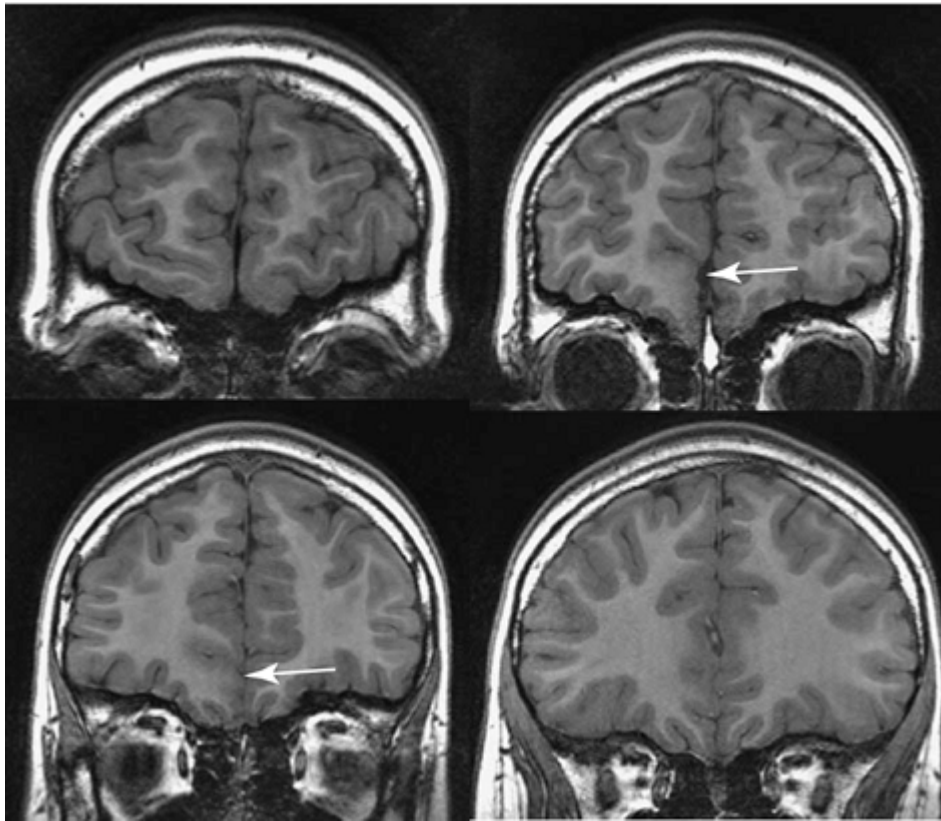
Subtle lesions require reliable boundaries between gray and white matter. These images show a focal cortical dysplasia in the medial and inferior aspect of the frontal lobe. The patient had frontal lobe epilepsy with lateralization to the right on ictal electroencephalogram. The identification of this lesion with concordant ictal single photon emission computed tomography led to focal resection of the lesion with good outcome without the need for implantation of subdural electrodes. The key to the recognition of this subtle lesion is the good signal-to-noise ratio of the imaging, which gives a clear gray–white matter demarcation.
